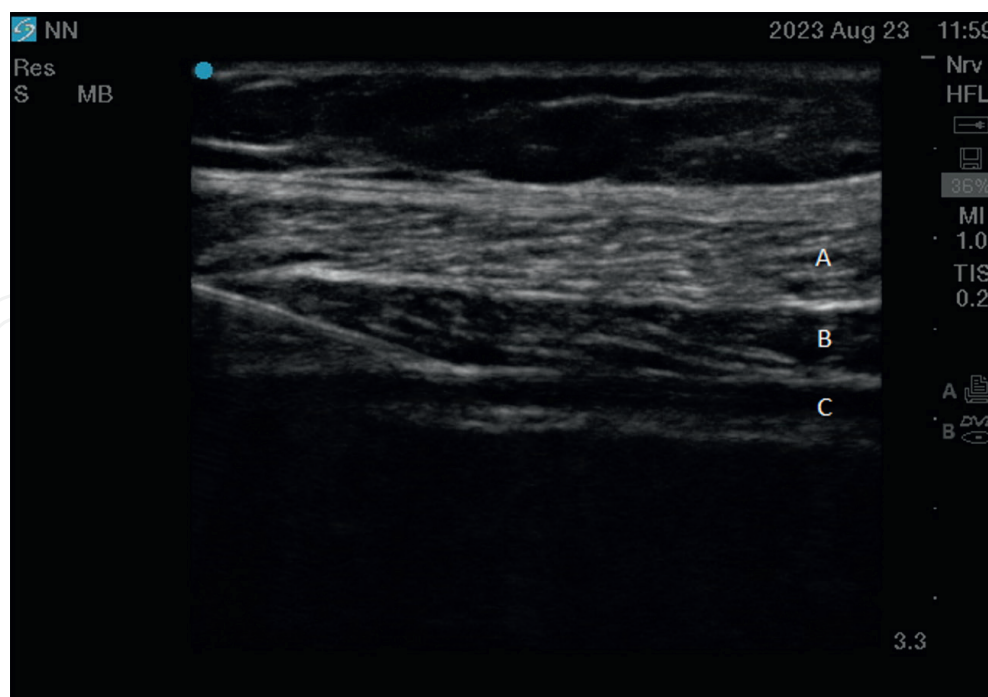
Ultrasound image (linear ultrasound probe) showing a plane needle and needle tip positioned in the transversus abdominis plane just before injecting the local anaesthetic. All three muscles of the abdominal wall are visualised: external oblique (A), internal oblique (B) and transversus abdominis muscle (C). (Author's archive).*
